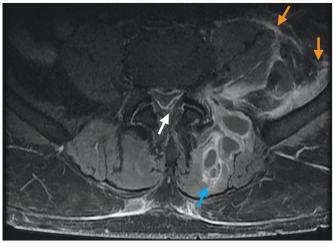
Axial, T1-weighted, fat-saturated, postcontrast magnetic resonance image at the L5 level demonstrates the multiloculated, rim-enhancing left paraspinal muscle abscess (blue arrow). Adjacent enhancement of the left psoas and iliacus muscles is consistent with myositis or intramuscular abscesses (orange arrows). The thin rimenhancing epidural abscess is partially visualized (white arrow).
